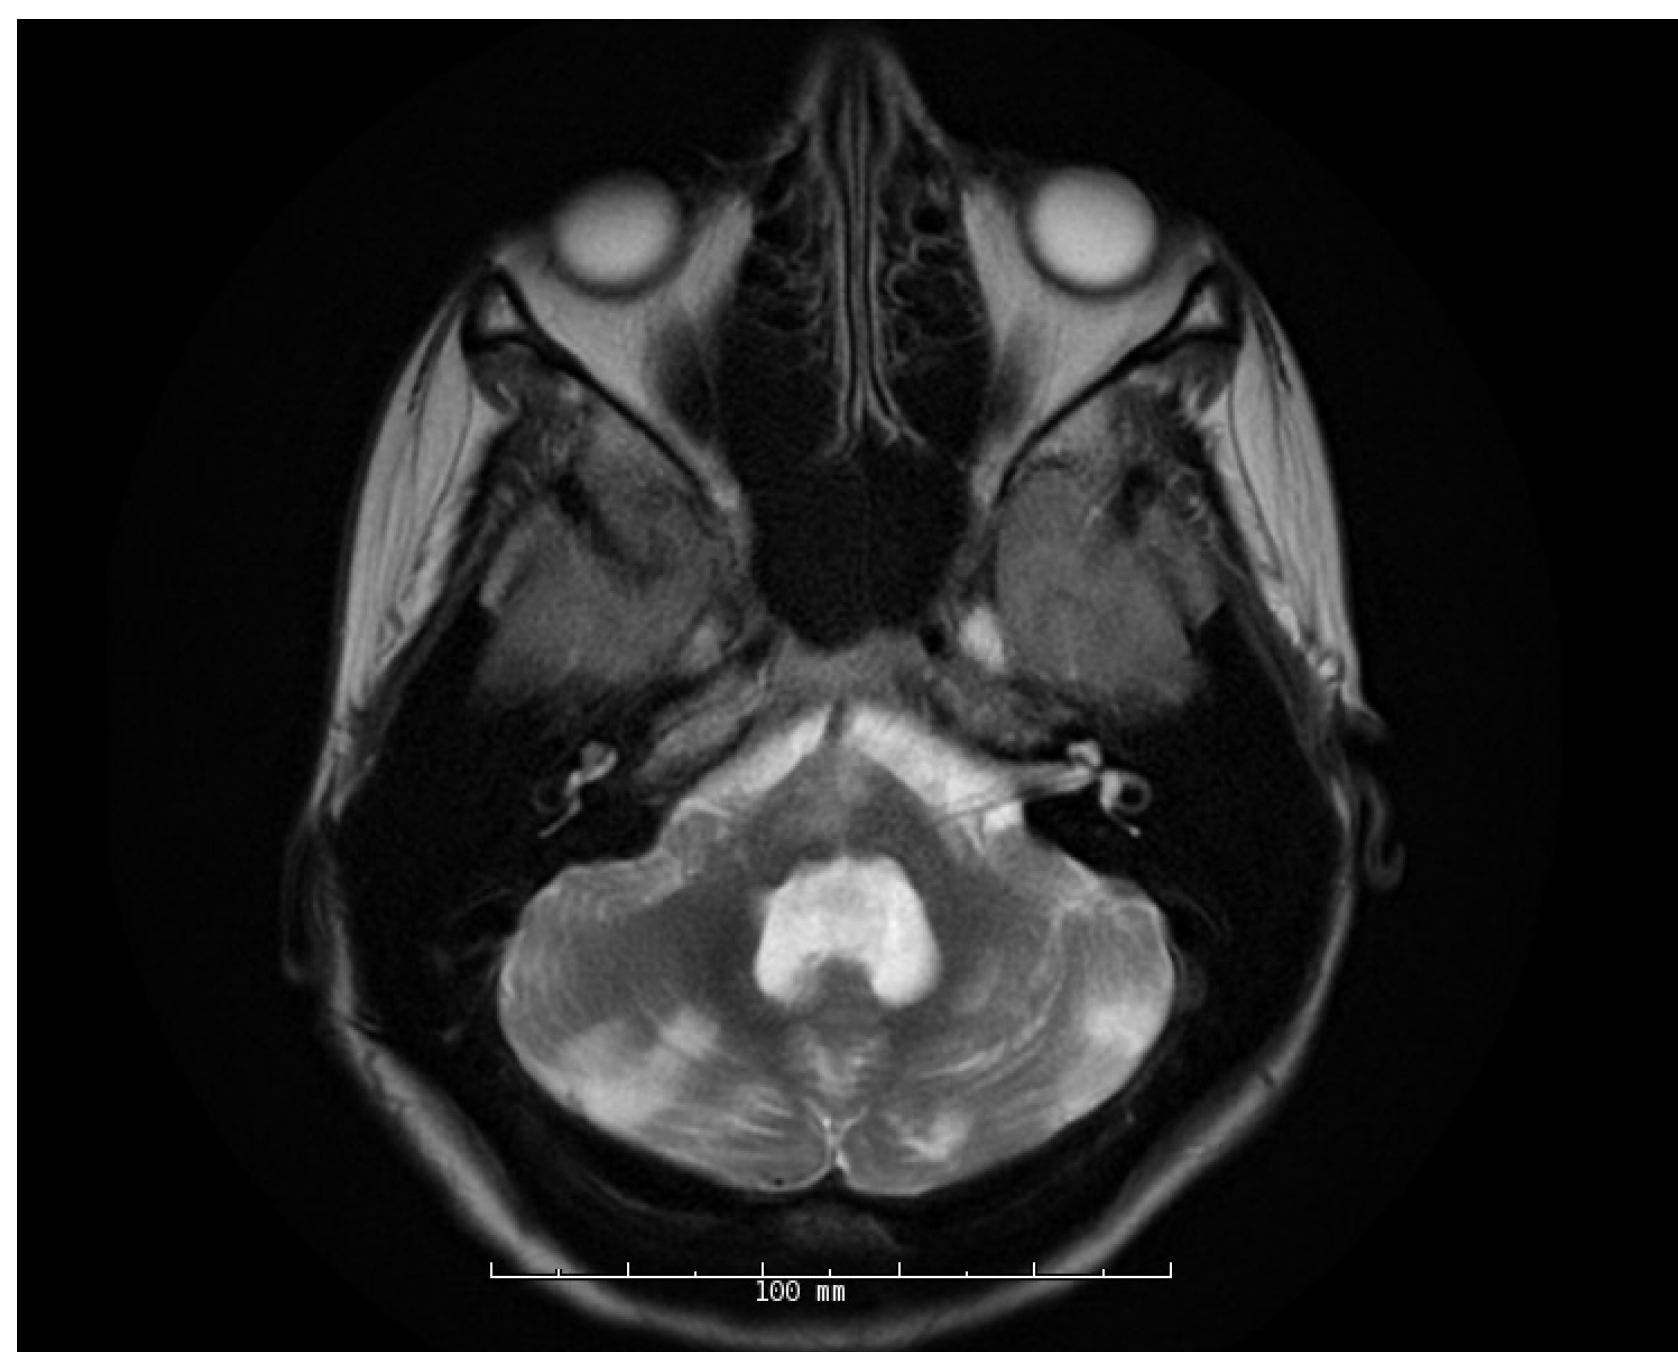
Axial T2 MRI Brain, demonstrating hyperintensities bilaterally in the cerebellum
